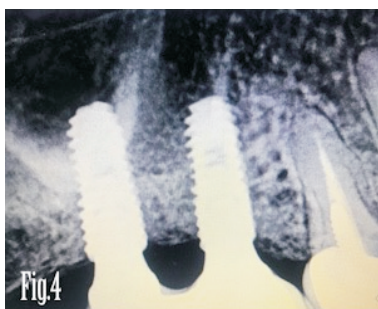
Radiograph showing maintained bone levels 3 months after loading
